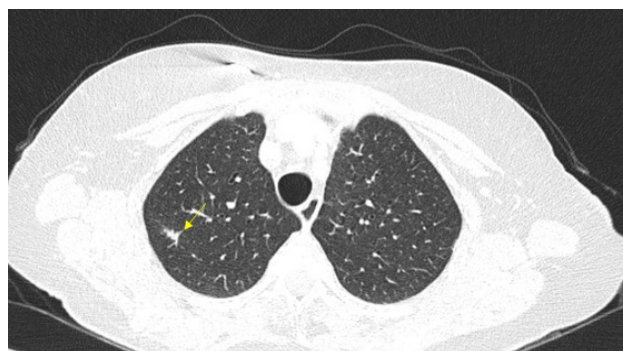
Computed tomography scan exhibiting a decrease in the pulmonary nodule from 15 mm to 10 mm, in largest diameter (arrow).
